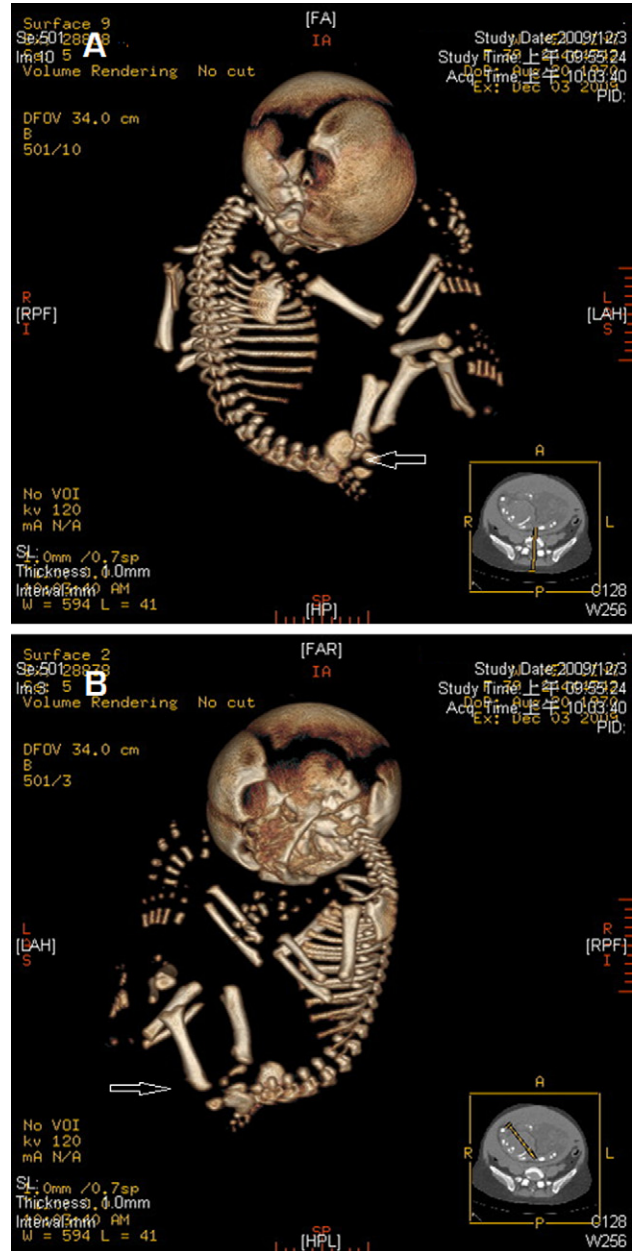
Three-dimensional helical computed tomography scan at near 33 weeks' gestation revealed (A) rhizomelic limbs, rounded iliac wings (arrowhead) and (B) bilateral "collar hoop" sign of the proximal femurs (arrowhead).
